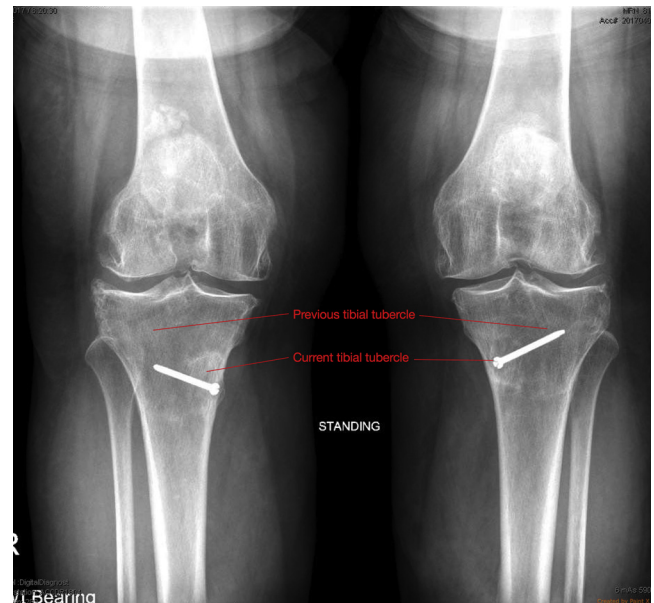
Case 2: Preoperative anterior-posterior radiographs. Note the location and trajectory of the screws.
